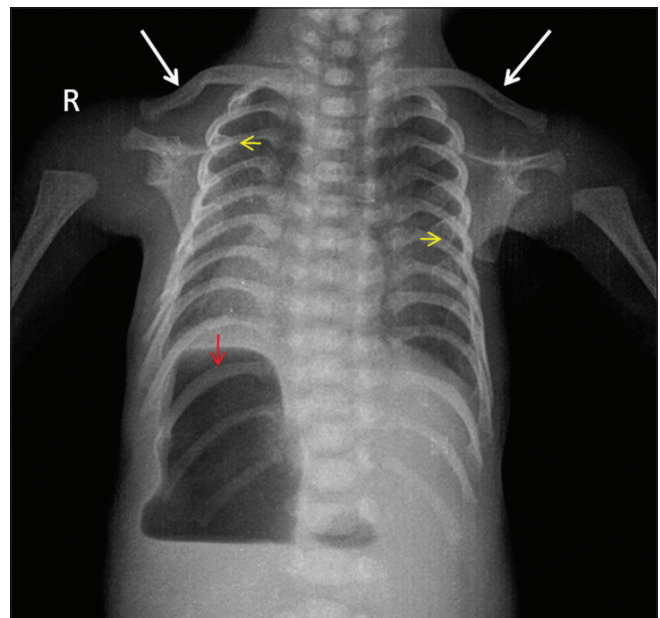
Plain radiograph of the thorax shows a narrow thorax, short, horizontally oriented ribs with expanded anterior ends (yellow arrows), "handle-bar" appearance of clavicles (white arrows) along with dextrocardia. Over-distended stomach is seen on the right side of the abdomen (red arrow)
